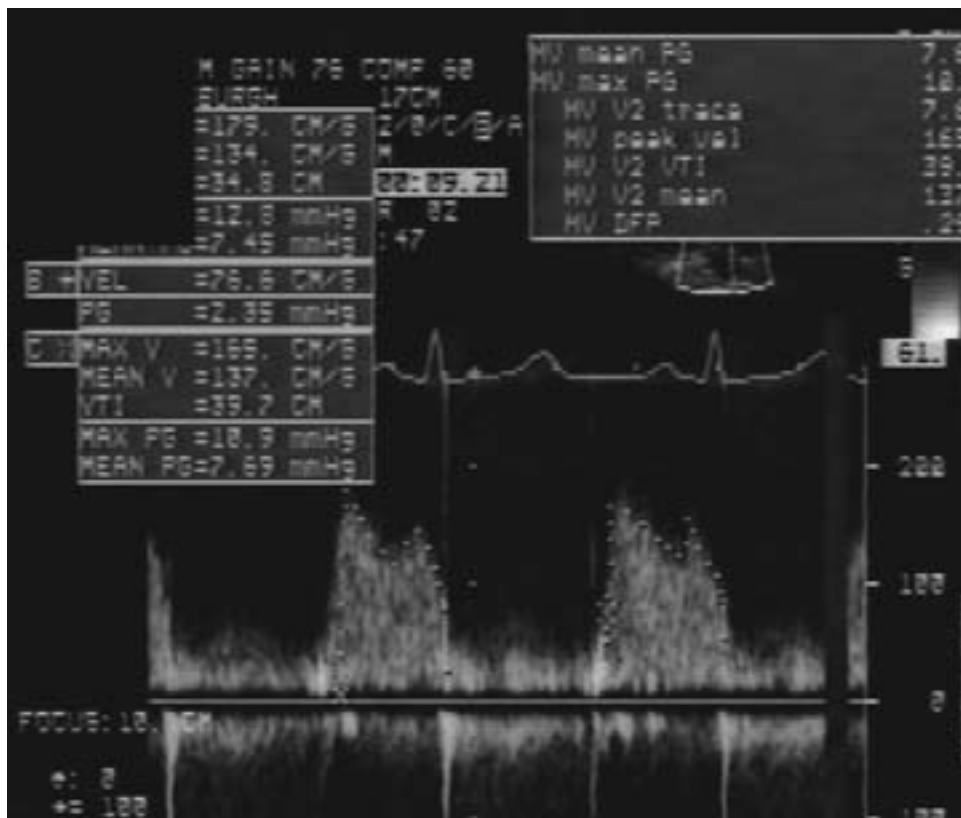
TTE CW Doppler signal of MV post balloon valvuloplasty, mean gradient = 7 mmHg.
